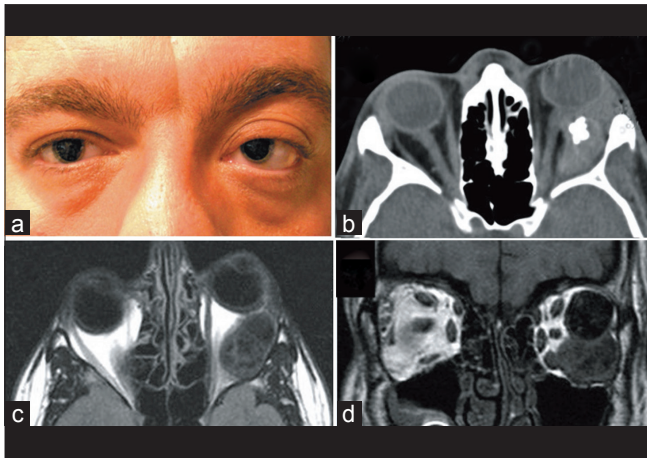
(a) Clinical photograph of the patient showing the axial proptosis in the left eye. (b) Computed tomography scan (axial view) of the orbit showing an oval, heterogeneous, well-defined mass measuring $2 \times 3.2 \times 4$ cm, free lying in the left orbit near the lateral orbital wall with moderate contrast enhancement and large central calcifications. There was bony remodeling with sparing of orbital structures. (c and d) Magnetic resonance imaging of the orbit (coronal and axial) showing heterogeneous lesion with hypointense areas corresponding to the calcification and hyperintense areas corresponding to the tumor mass
